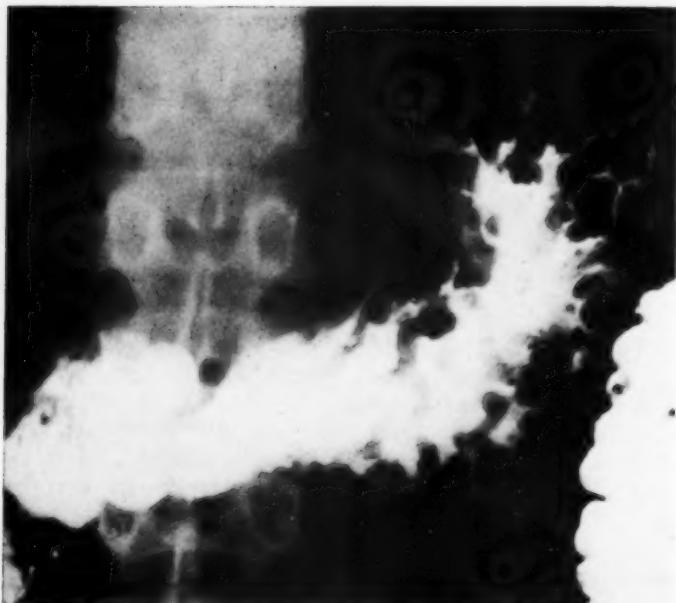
Relief roentgenogram showing the large shallow filling defect on the lesser curvature of the stomach (arrow). Note the enlarged mucosal rugae and the wide, deep, sharp rugal folds along the greater curvature.
